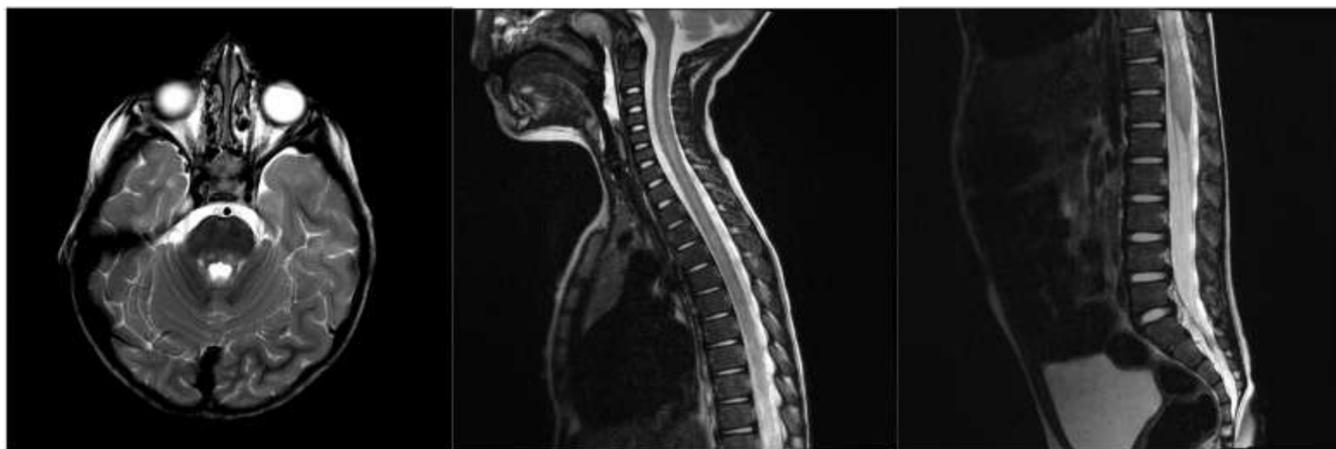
MRI images of patient 3, displaying increased T2 signal within the central gray matter of the entire spinal cord, as well as the dorsal pons (the image on the left was enlarged to match the size of the other 2).
